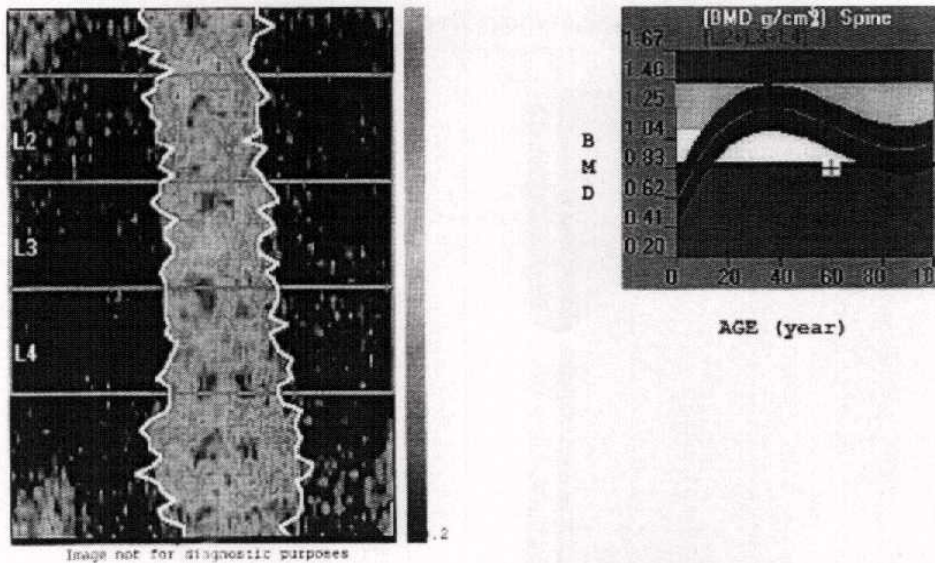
Dual energy x-ray absorptiometry (DEXA) -bone densitometry- revealed: lumbar vertebrae showing total bone mineral density (BMD) of 1.045 g/cm<sup>2</sup> with a T-score of -1.5 denoting osteopenia with increased fracture risk at this region.
